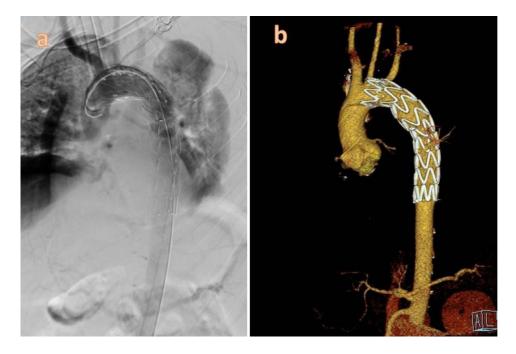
Endovascular stent-graft (Valiant Captivia, Medtronic) was successfully implanted (A). Three months after the procedure, follow-up computed tomography angiography showed that the stent-graft was correctly positioned in the descending aorta (B).
